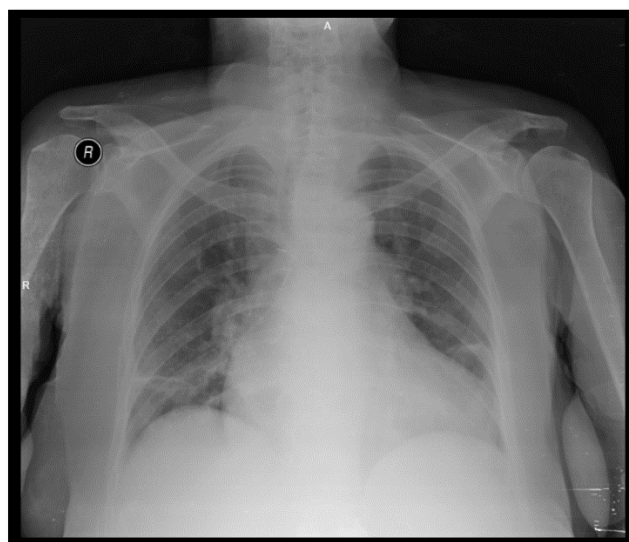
Posteroanterior chest X-ray of the patient at the first presentation
